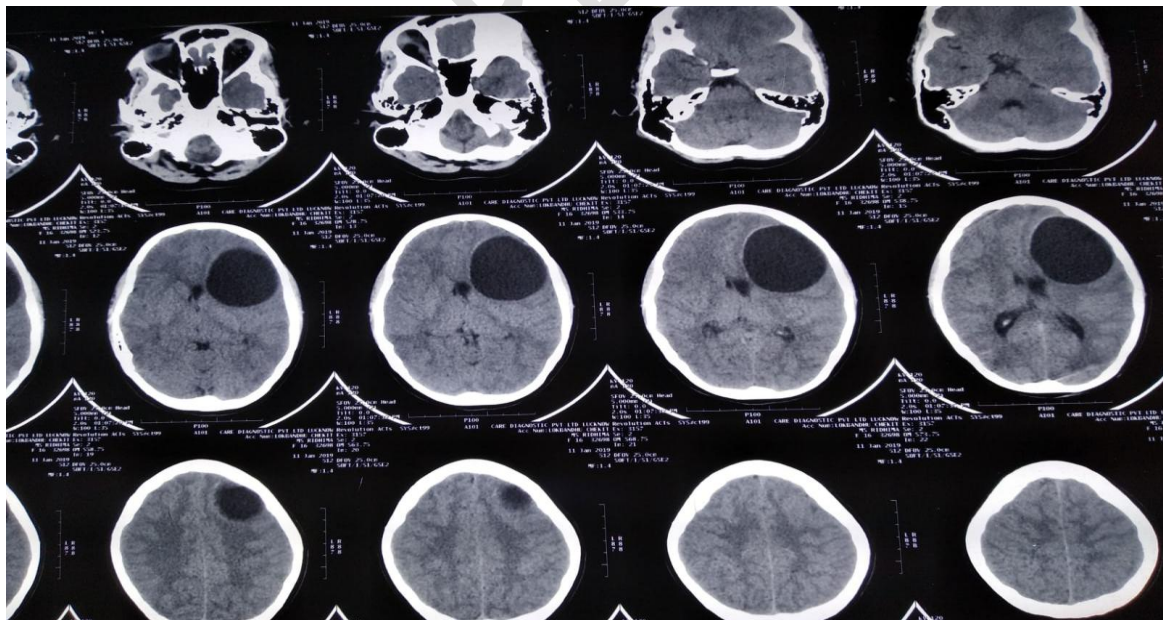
Postoperative Contrast enhanced computed tomography image of space occupying lesion in the frontal lobe
